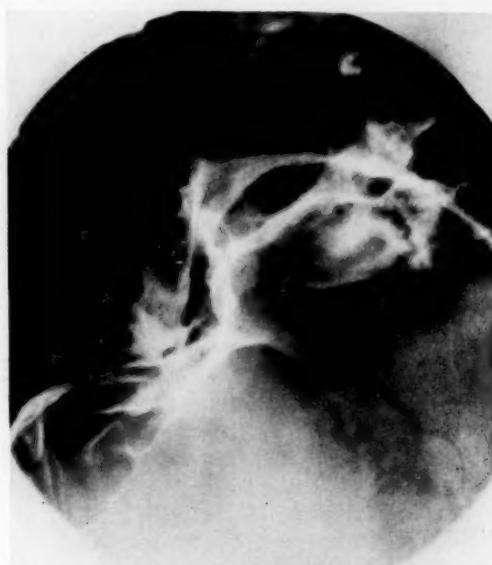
X-ray (Stenver's position) showing transverse fracture of pyramid eight and one-half years after its occurrence.
